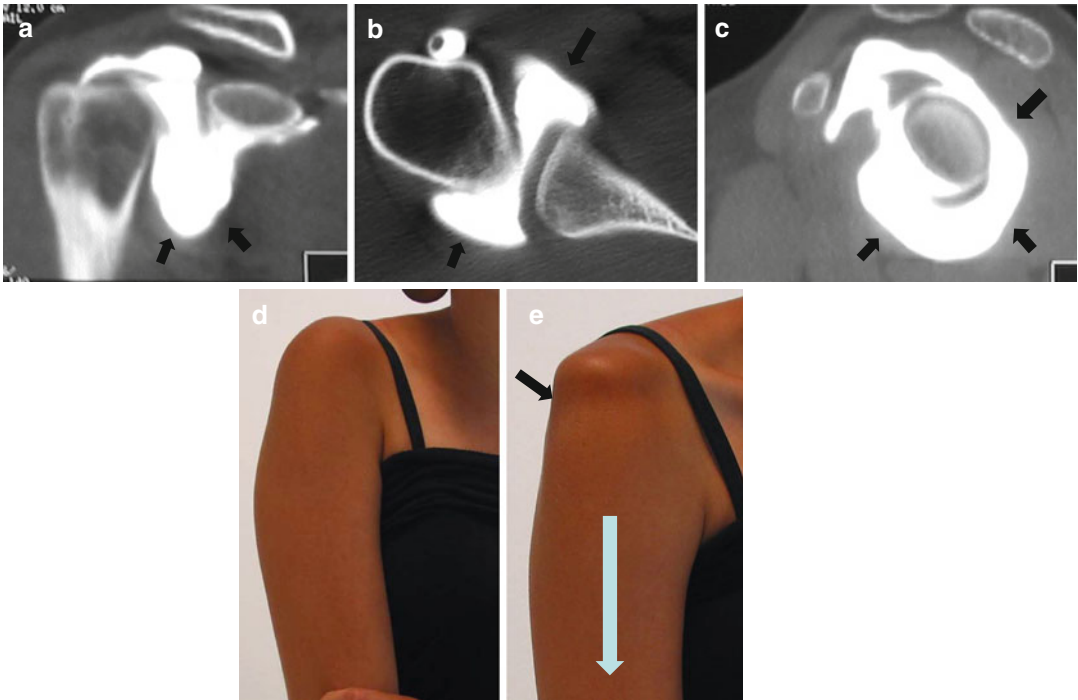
Multi-directional instability (a–e). Arthro-CT demonstrates a large capsular pouch (arrows) seen in the transverse (a), frontal (b) and sagittal (c) cuts. Normal
